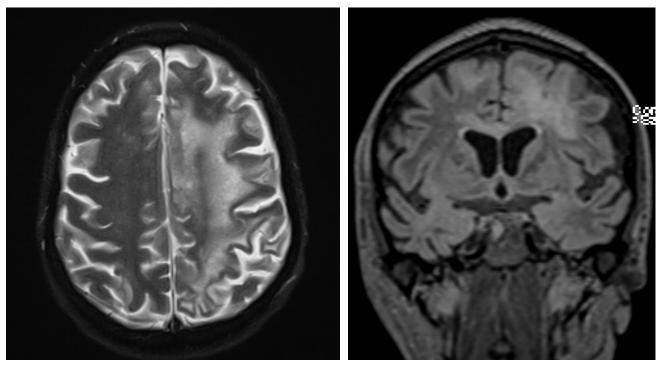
Brain MRI imaging showed left subcortical frontoparietal white matter high T2/flair signal intensity lesions crossing the corpus callosum into the right frontal lobe with some restricted diffusions peripherally without significant enhancement
